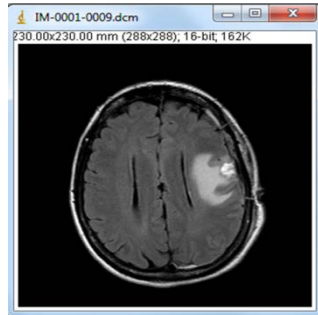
Axial section of Brain MRI image
